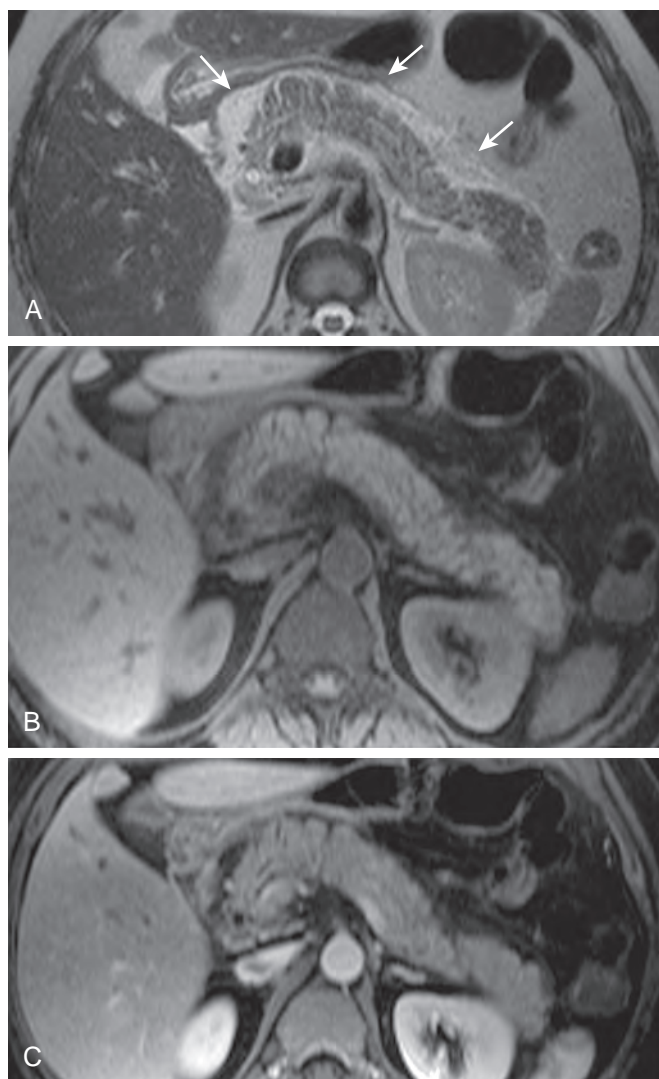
Mild ERCP-induced pancreatitis. A. Axial T2-weighted half-Fourier acquisition single-shot turbo spin-echo (HASTE) MR image shows peripancreatic fluid (arrows) with high signal intensity. The pancreas also has mildly increased signal intensity due to edema. B. Axial T1-weighted fat-suppressed spoiled gradient-echo MR image shows normal high signal intensity of the pancreas in this patient with uncomplicated pancreatitis. The peripancreatic fluid is better seen on T2-weighted images. C. The pancreas shows diffusely decreased enhancement during the arterial phase after administration of gadolinium. (A-C from Miller FH, Keppke AL, Dalal K, et al: *MRI of pancreatitis and its complications: Part 1, acute pancreatitis*. AJR Am J Roentgenol 183:1637–1644, 2004. Reprinted with permission from the American Journal of Roentgenology.)
